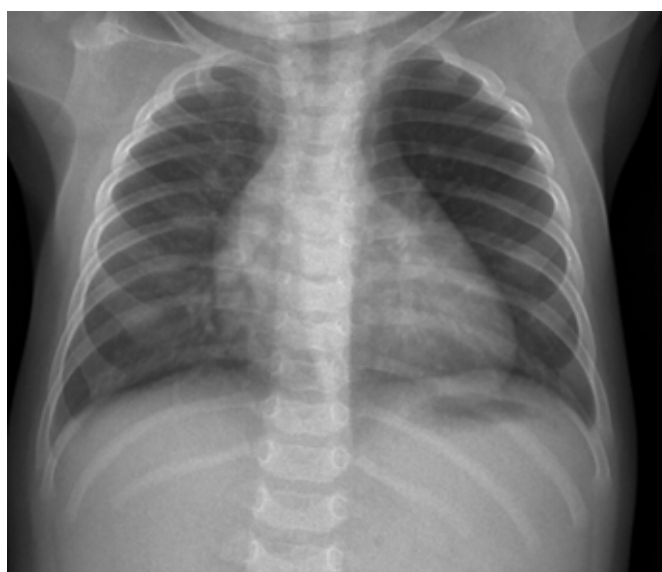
Chest X-ray of an Infant of 4 months, antero-posterior projection, showing diffuse bronchi walls thickening in favor of bronchiolitis. The heart is normal in shape and size. The pleural cavity is free
